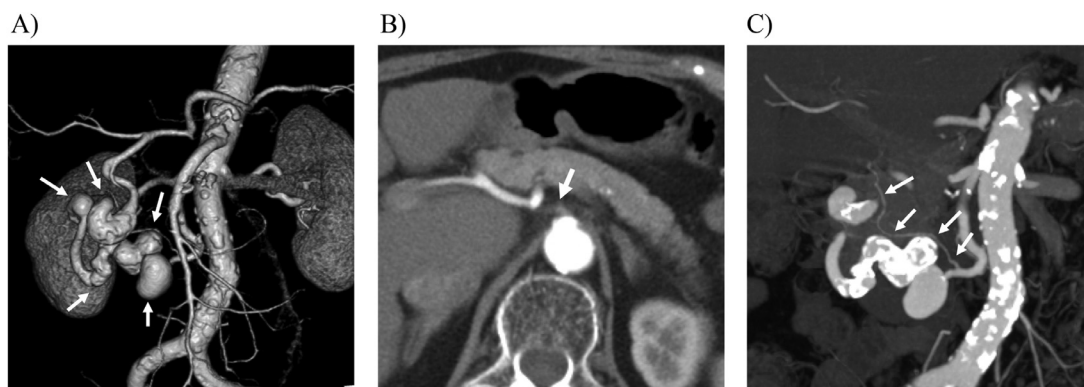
(A) 3D-CTA revealed multiple large aneurysms of the anterior superior pancreaticoduodenal artery (arrows). (B) An axial image showed occlusion of the celiac artery (arrow). (C) A coronal image showed the posterior superior pancreaticoduodenal artery was very thin (arrows).
